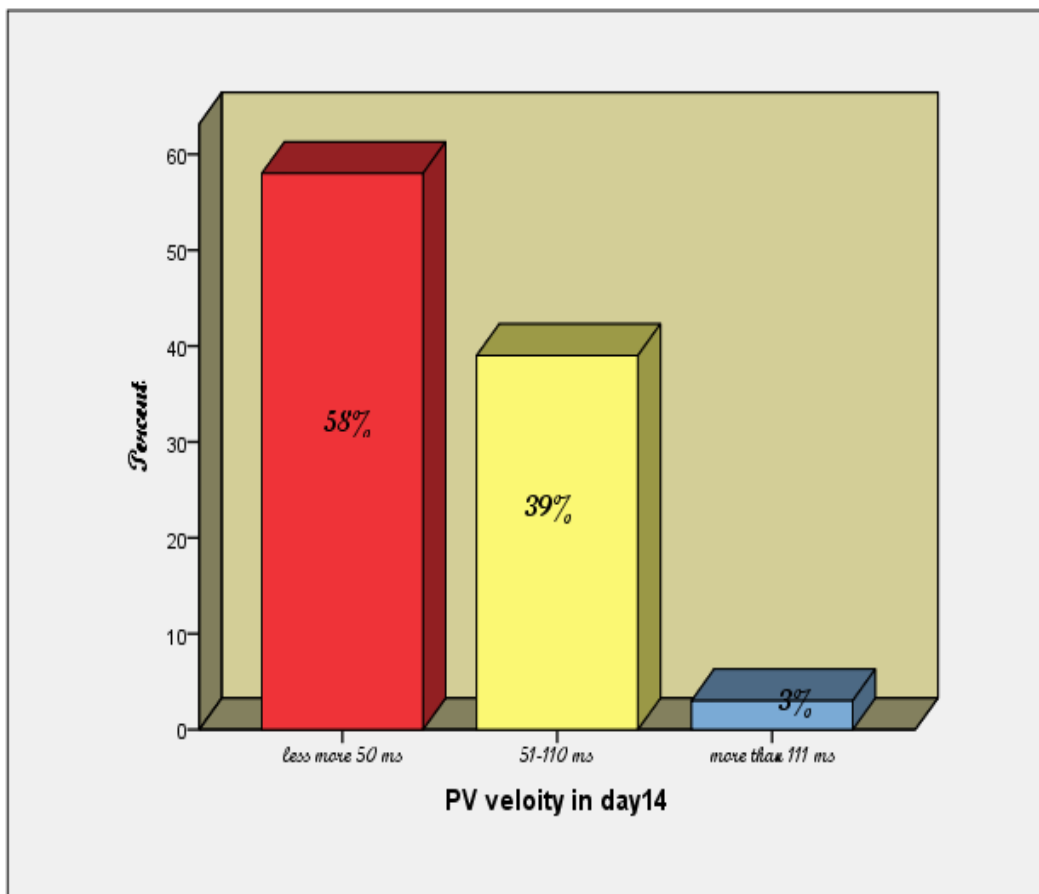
Frequency distribution of spectral Doppler for portal vein in day 14
